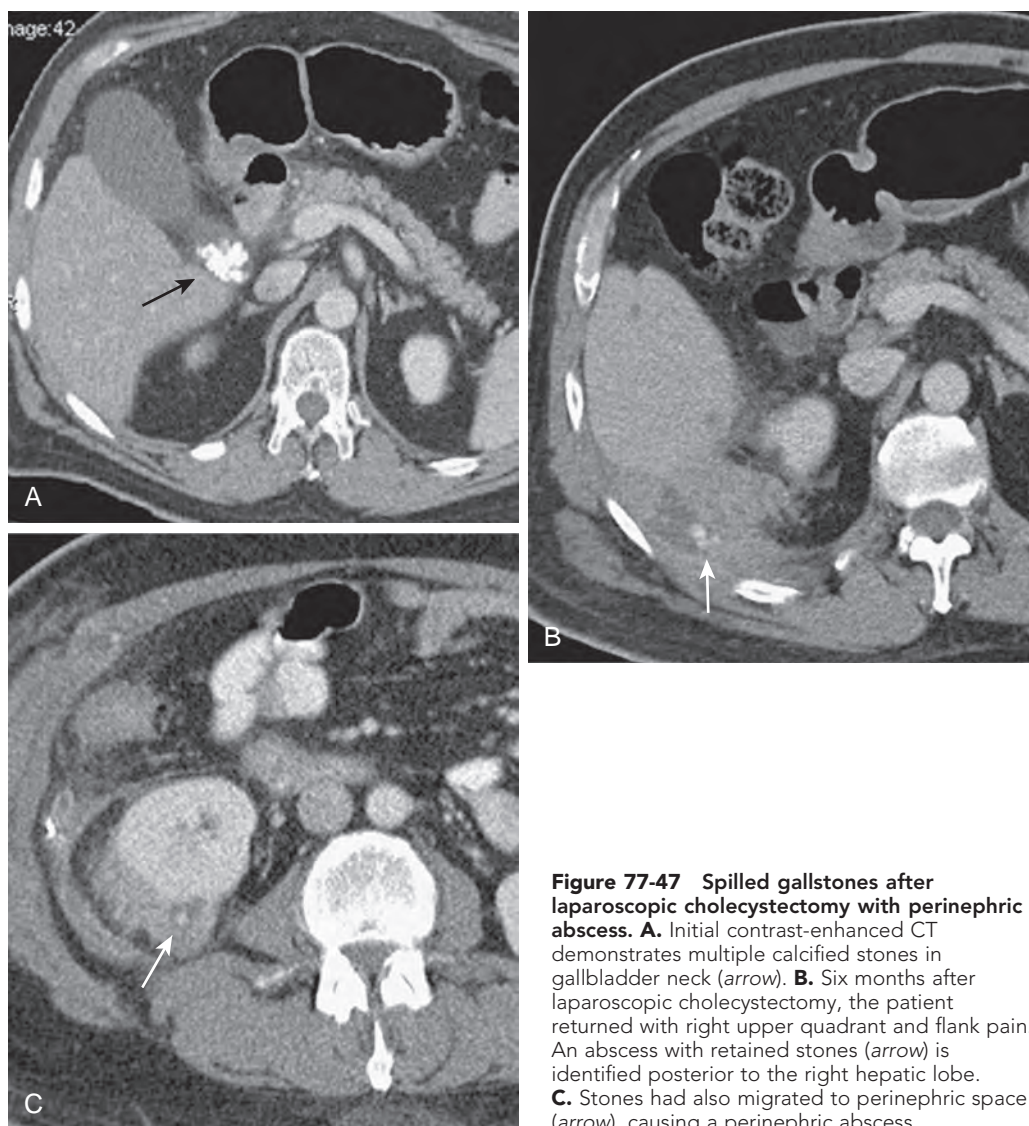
Spilled gallstones after laparoscopic cholecystectomy with perinephric abscess. A. Initial contrast-enhanced CT demonstrates multiple calcified stones in gallbladder neck (arrow). B. Six months after laparoscopic cholecystectomy, the patient returned with right upper quadrant and flank pain. An abscess with retained stones (arrow) is identified posterior to the right hepatic lobe. C. Stones had also migrated to perinephric space (arrow), causing a perinephric abscess.
